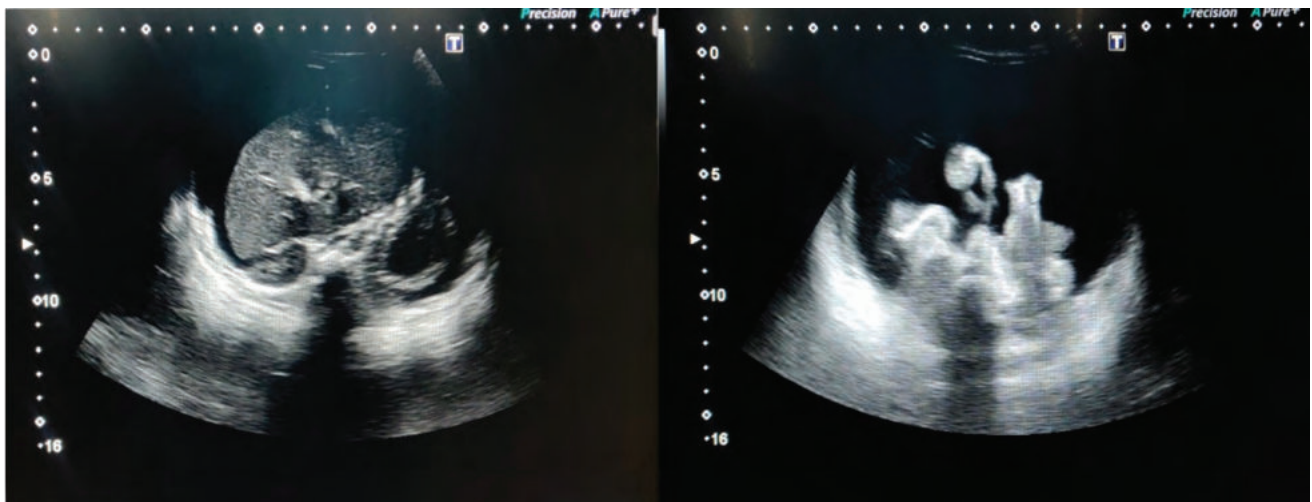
Ultrasound image displaying extensive ascites throughout the abdomen.
